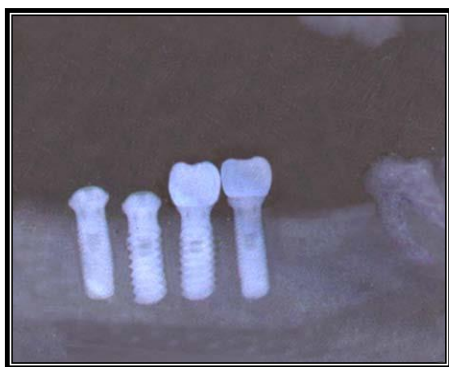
Radiographic X-ray film of the implants with the abutments after 3 months of implants placement
